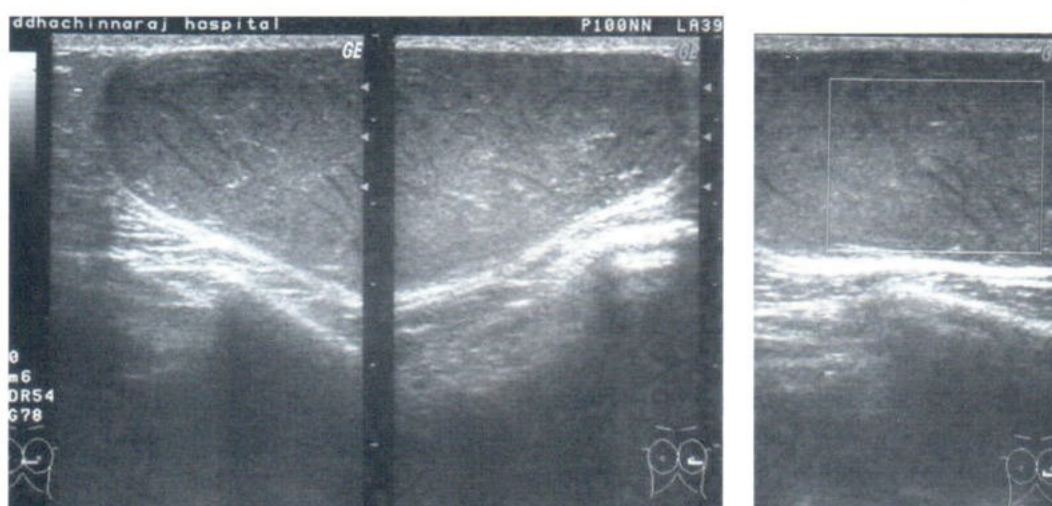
(A) Transverse US scan shows a large well-circumscribed hypoechoic mass with posterior enhancement. (B) Color Doppler US scan shows no vascular flow inside the mass.
